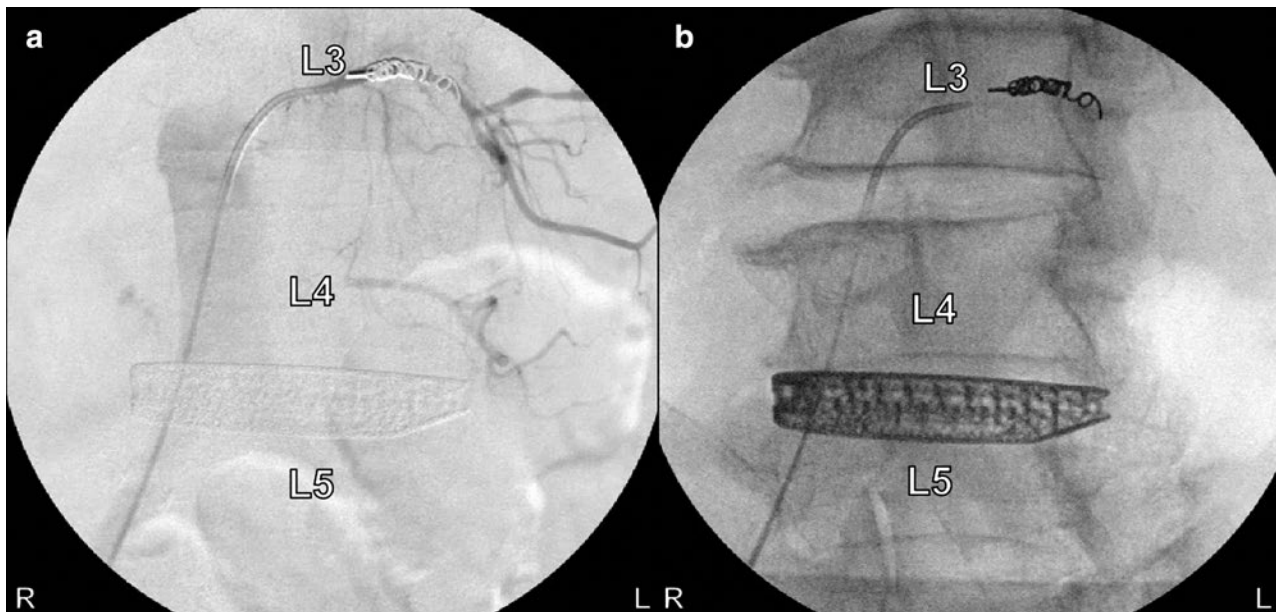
Intraoperative angiography images after coil placement into the left L3 segmental artery. (a) Anteroposterior digital subtracted angiogram with catheterization of the left L3 segmental artery. The coil was placed and detached. (b) Anteroposterior X-ray obtained while the left L3 segmental artery was still catheterized demonstrates the final coil position in reference to the bony anatomy.
